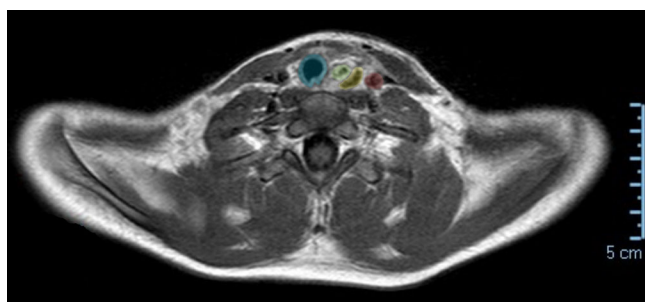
◀ Post-operative MRI of transversal axis. Trachea (blue), oesophageal wall thickened significantly less (green), collagen fleece (yellow) between esophagus and ACC (red)
